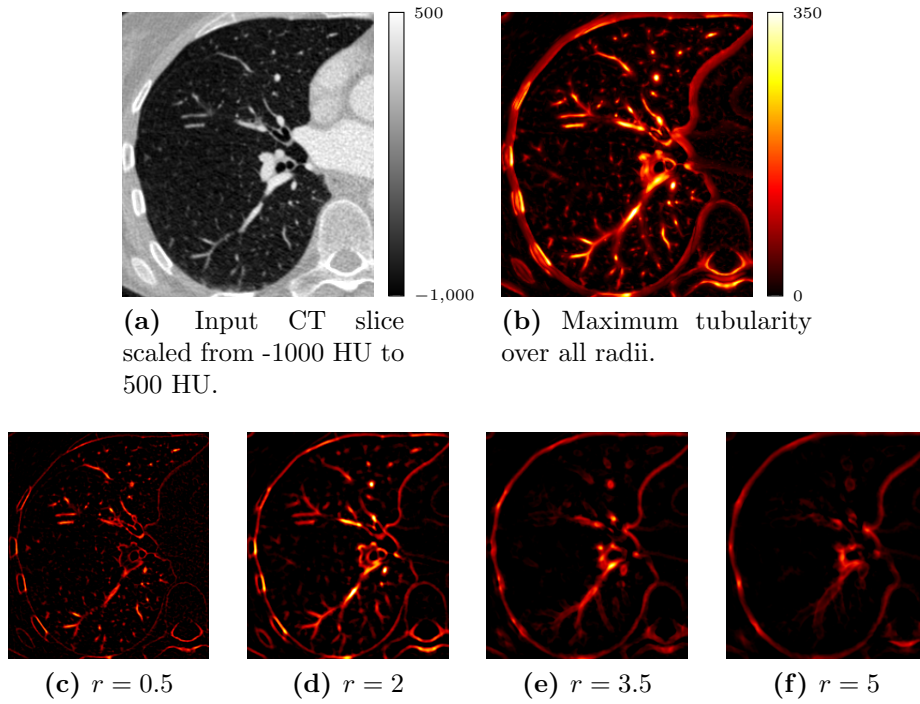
Visualization (a) shows a slice of the input *CT* image and (b) its 4D vessel enhancement result. The images in the bottom row ((c), (d), (e), and (f)) show the vessel enhancement output for various radii. The final 4D vessel enhancement image is composed of the 3D vessel enhancement images for all computed radii.
